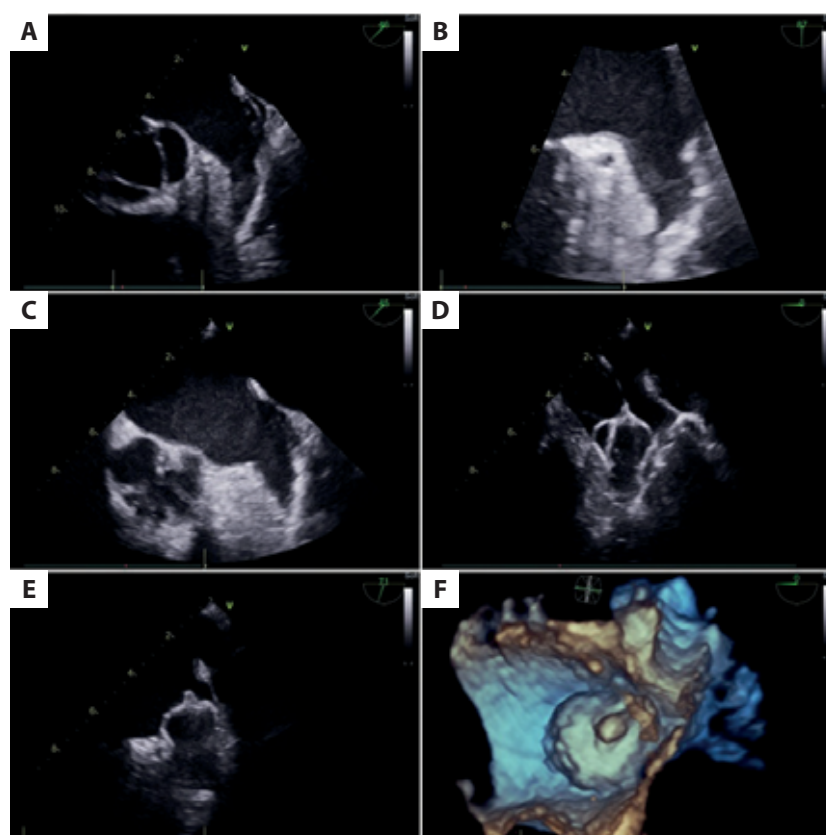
A. Thrombus of diameter 0.8 cm in the LAA. B. Spontaneous contrast in the LAA, which has gelatinous consistency on the bottom and is on the verge of clotting. C. Spontaneous contrast in the LAA. D. A 35 mm Watchman FLX device in the LAA, before release, intraprocedural 2D TEE. E. A 35 mm Watchman FLX device in the LAA after release, intraprocedural 2D TEE. F. A 35 mm Watchman FLX device in the LAA after release, intraprocedural 3D TEE. Abbreviations: 3D, 3-dimensional; 2D, two-dimensional; LAA, left atrial appendage; TEE, transesophageal echocardiography
